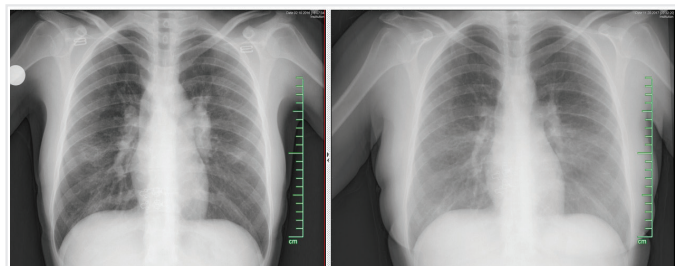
Comparison of posteroanterior X-ray of the patient before and after treatment
